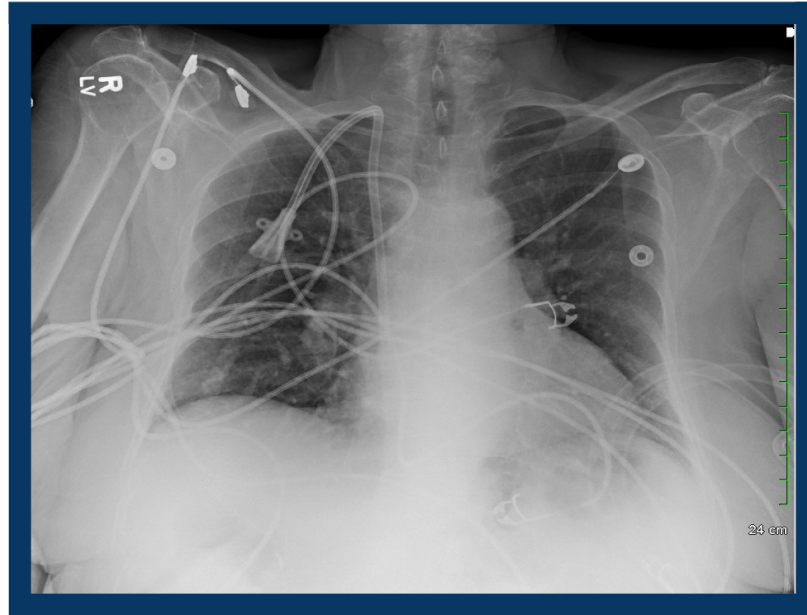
Chest X-ray demonstrating increased pulmonary vascular markings and peribronchial cuffing.
